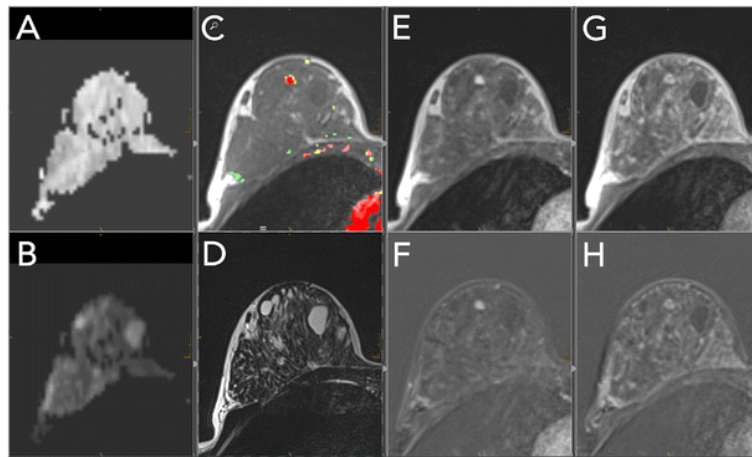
Example of standardized hanging protocol for breast MRI (from [16]). The layout consists of ADC map (A), a high b-value DWI image (B), a pre-contrast T1-weighted image (C) and a T2-weighted image (D), followed by early and delayed post-contrast images with corresponding subtractions (E-H) [16].
